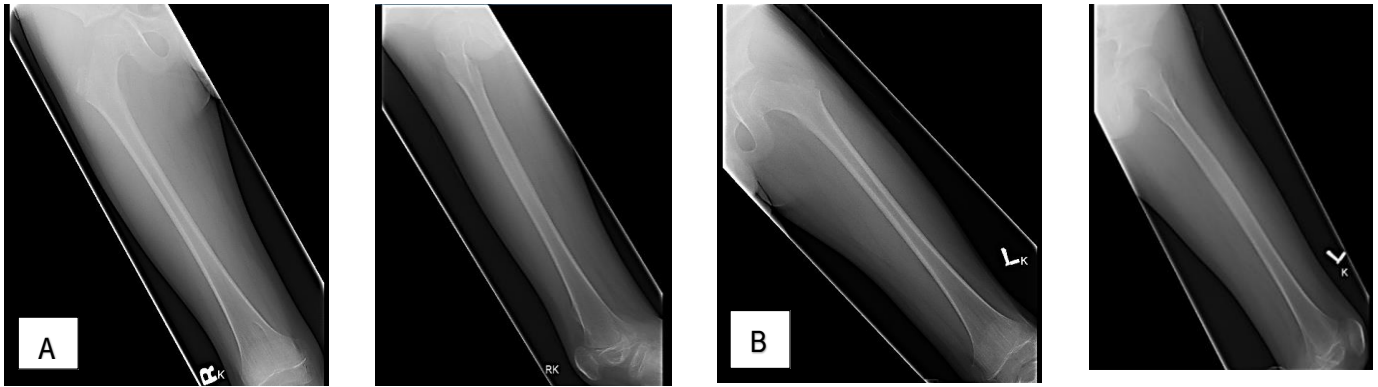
A, AP/lateral plain radiograph of the right femur; B, AP/lateral plain radiograph of the left femur.
